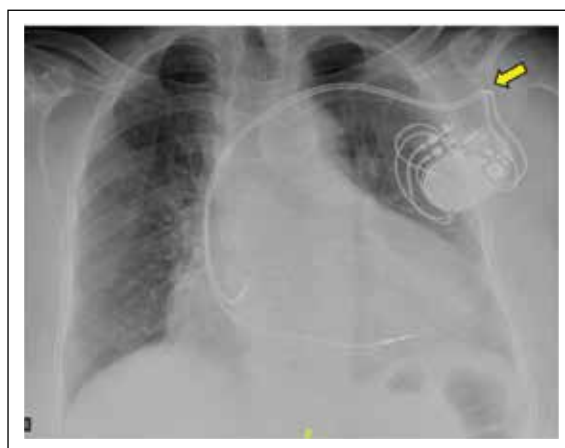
Frontal chest radiograph of a patient with sick sinus syndrome, who underwent double chamber pacemaker implantation. Note the acute bend (arrow), which should be avoided during implantation as it might lead to long-term stress over the lead conductors and may result in fracture of the conductor/ lead.
